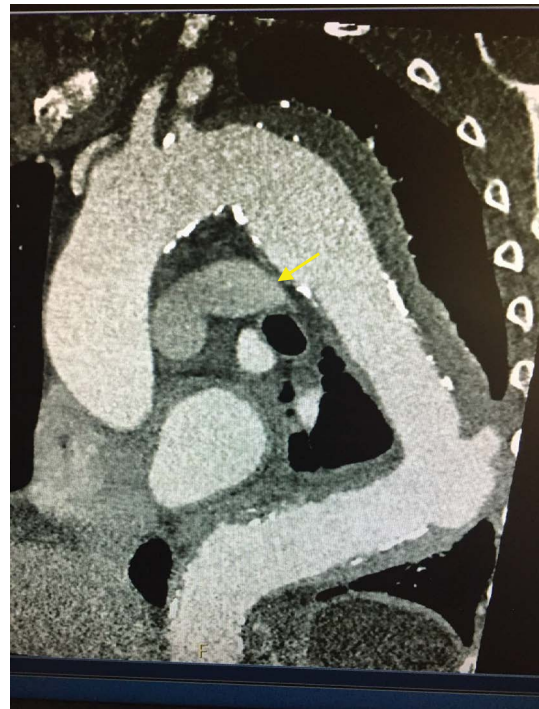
CT angiogram of aorta showing intramural hematoma distal to left subclavian involving the thoracic aorta and extending to the diaphragm (arrow).
